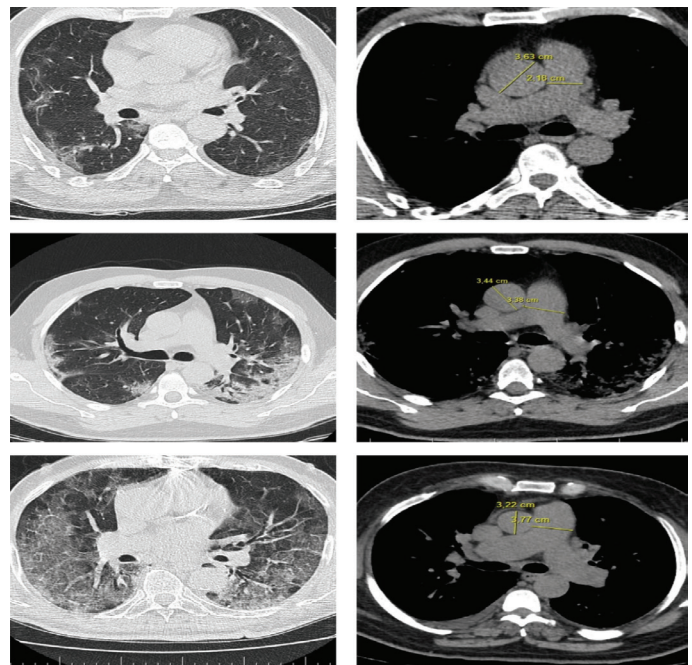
Axial images of non-contrast chest computed tomography demonstrating measurement of lung involvement due to Coronavirus disease-2019 and the corresponding pulmonary image in the parenchyma window. Increased pulmonary artery/ascending aorta (PA/AA) ratio was associated with the severity of lung involvement. The PA/AA ratios were 0.6-0.98-1.17, respectively
